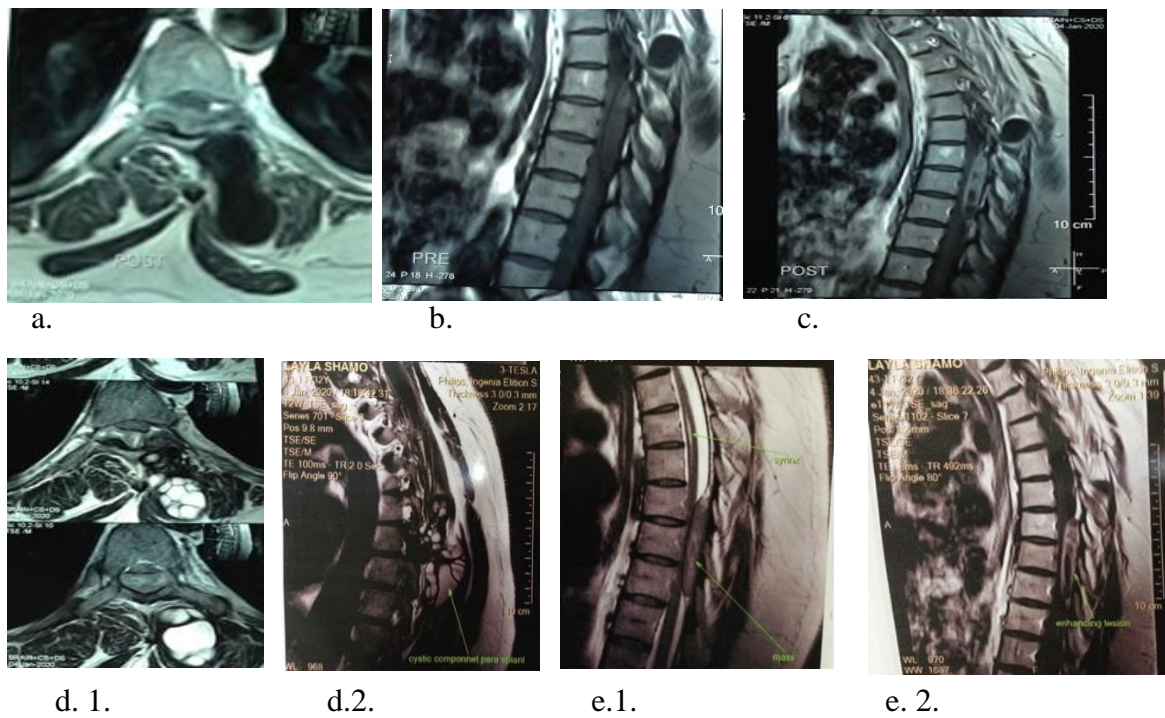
Pre-operative MR images, pre-and post-contrast T1W and T2W phases (a-e).
